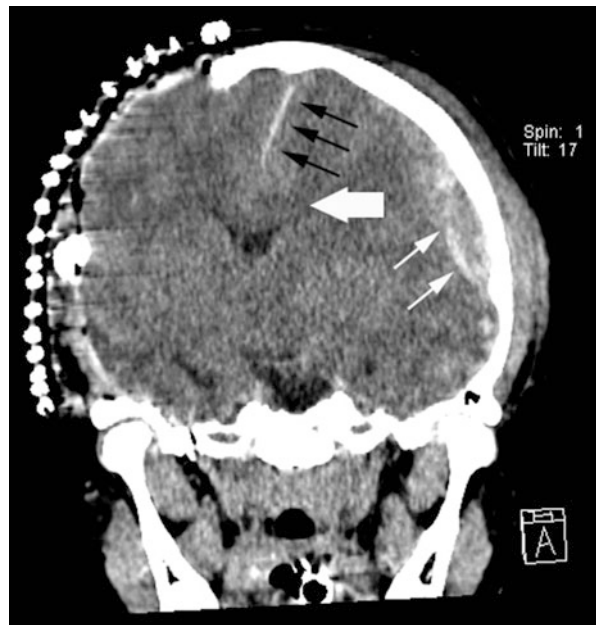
Subfalcine herniation. A coronal noncontrast CT from the same patient as in Fig. 20.5 demonstrates shifting of the brain (*large white arrow*) to the right underneath the free edge of the falx cerebri (*black arrows*) as a result of a large left-sided epidural hematoma (*small white arrows*). The patient had undergone right frontal parietal craniectomy with overlying skin staples
